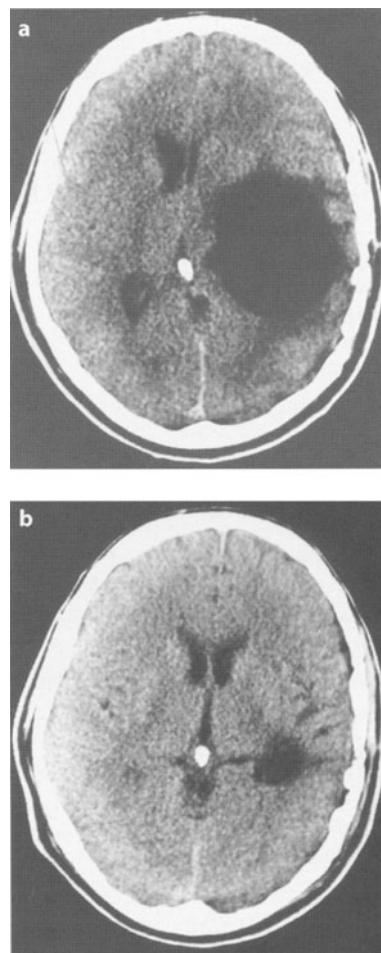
a, b. Axial CT scans. a Blockage of temporal horn by ependymitis. b Postoperative follow-up after endoscopy
